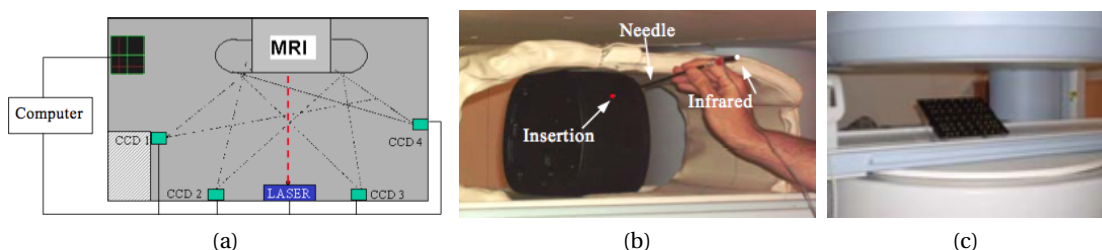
Optical tracking of needle insertion (a): Disposition of the CCD cameras and the laser pointing device in the MRI room. (b): Needle insertion point indicated by a laser pointer. The needle is tracked by the camera with an infrared LED attached to its distal end. (c): A calibration frame, visible for the cameras and for the MRI is used for permanent registration of the camera system with the MRI scanner. Reprinted from [VBR<sup>+</sup>07].
